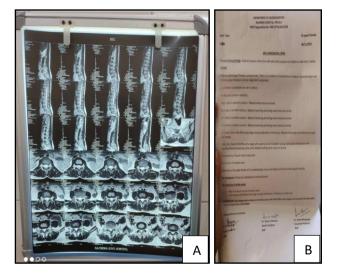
(A) Radiological investigation-MRI of lumbar spine (film). (B) Radiological investigation-MRI of lumbar spine (report).
